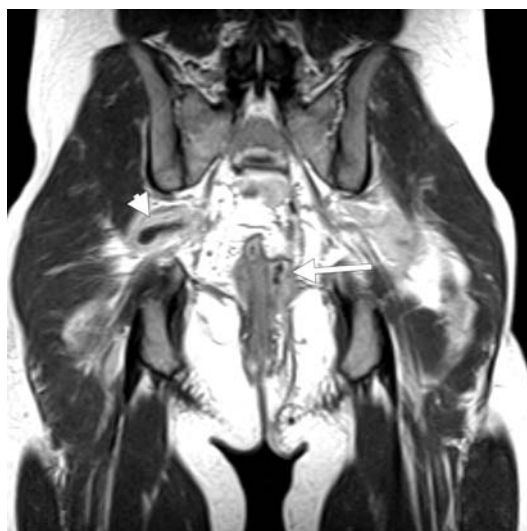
Coronal post-contrast T1- weighted MR image shows an irregular area of higher signal intensity in the supralevator space indicating presence of inflammatory tissue (*arrows*) and abscess (*arrowhead*).
